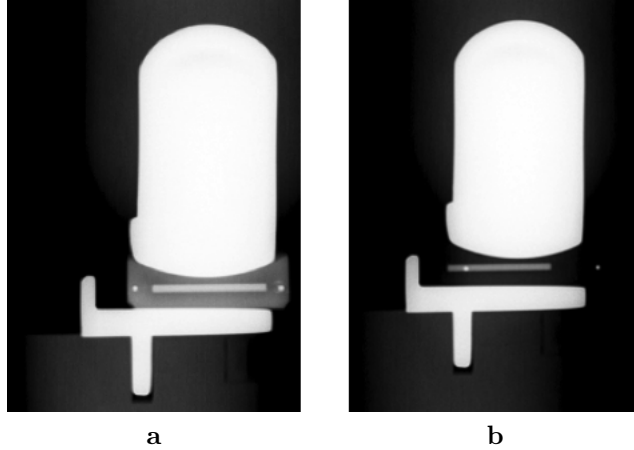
a) The amount of overhanging of the bearing (size 4) can be identified directly from a radiograph due to the visibility of the bearing b) The overhanging can be confirmed from the radiographic markers, but the amount of overhang is harder to quantify.
